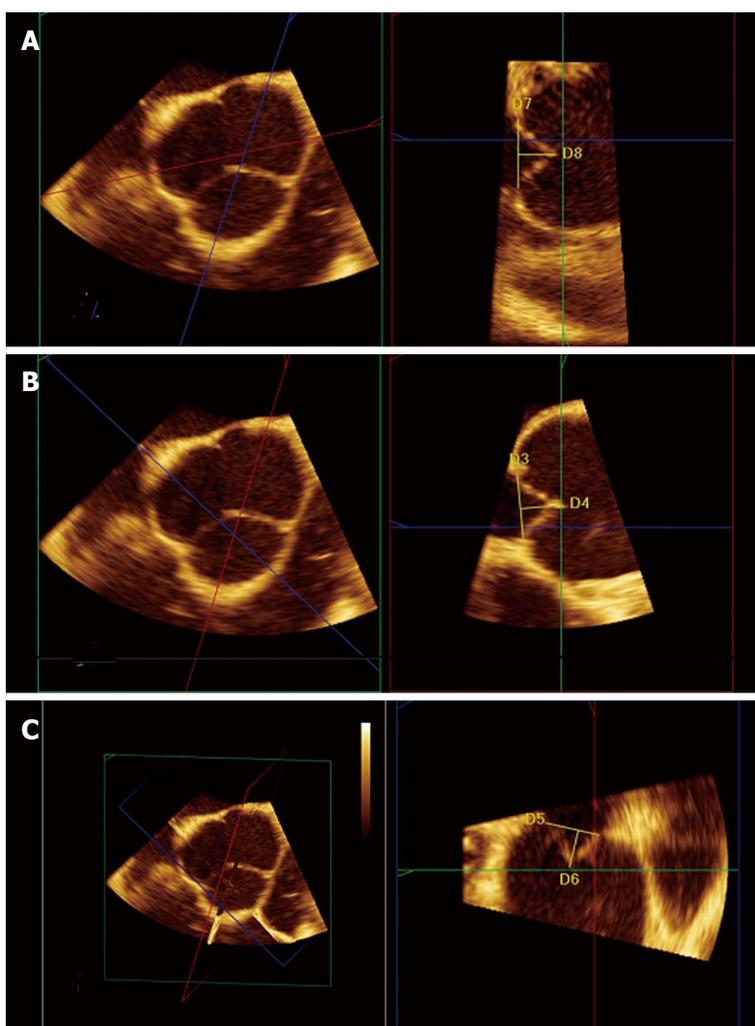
Images of a normal aortic valve from multiple plane reconstruction of the aortic valve with 3D transesophageal echocardiography. A: The red plane intersects the coaptation surface of the noncoronary cusp (NCC) and left coronary cusps (LCC) The yellow line labelled D8 (12.7 mm) represents the LCC effective height; B: The red plane intersects the coaptation surface of the LCC and right coronary cusps (RCC) The yellow line labelled D4 (13.9 mm) represents the effective height; C: The red plane intersects the coaptation surface of the NCC and RCC. The yellow line labelled D6 (12.7 mm) represents the effective height.
